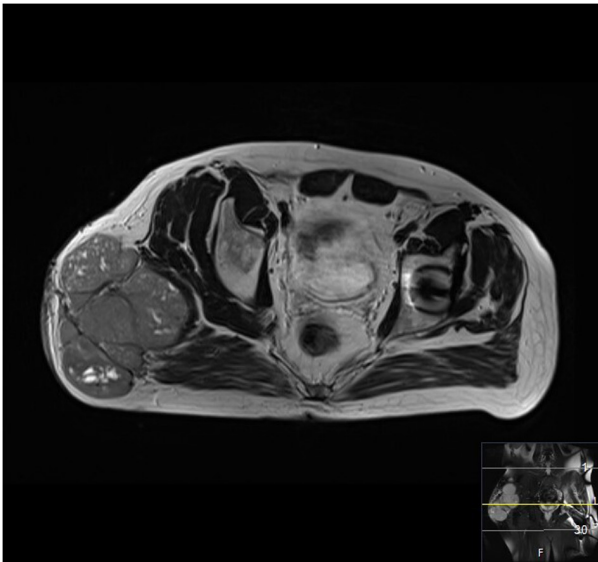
MRI axial view of the tumor (2012). MRI, magnetic resonance imaging.
